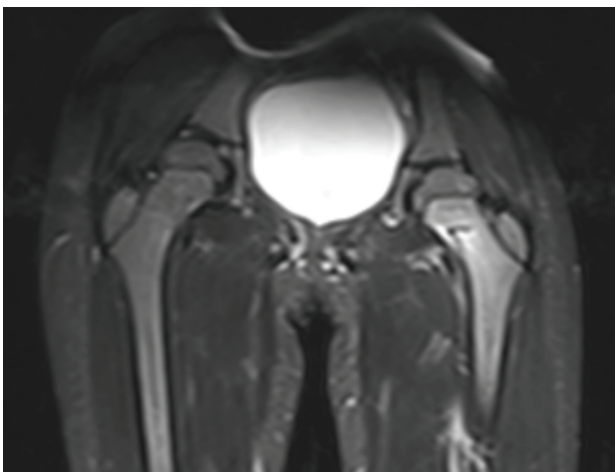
Magnetic resonance imaging: Left femoral neck stress fracture and surrounding bone edema were visible on the T2 sequence
